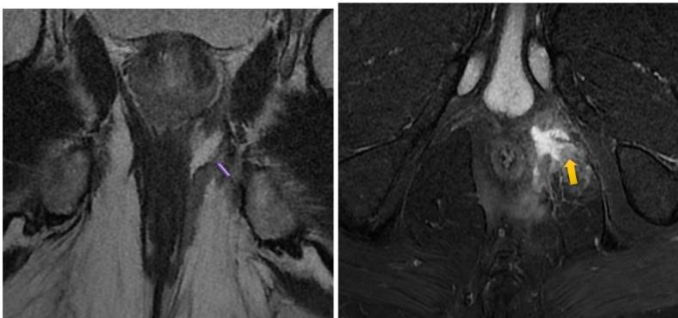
Coronal T2 weighted (A) and axial T2 weighted (B) FS MR images showing supralelevator abscess with translevator fistula – GRADE 5
